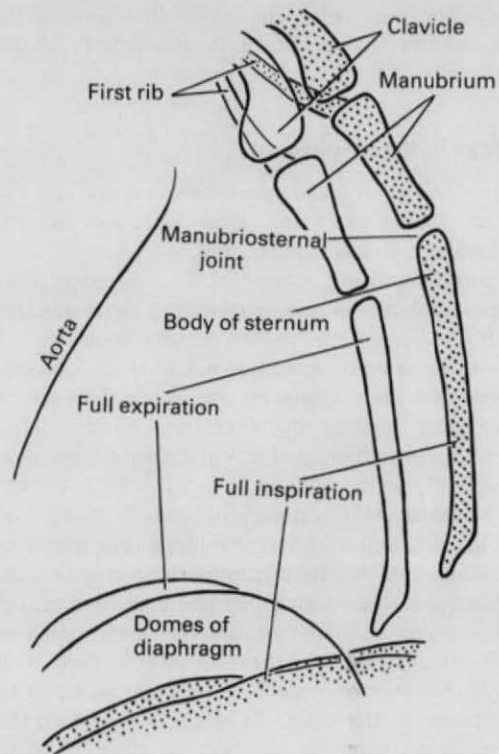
Movements of the sternum and diaphragm during respiration. The outlines were traced from a lateral radiograph. In full expiration the manubriosternal angle measures 161° ; this changes to 154° in full inspiration.
